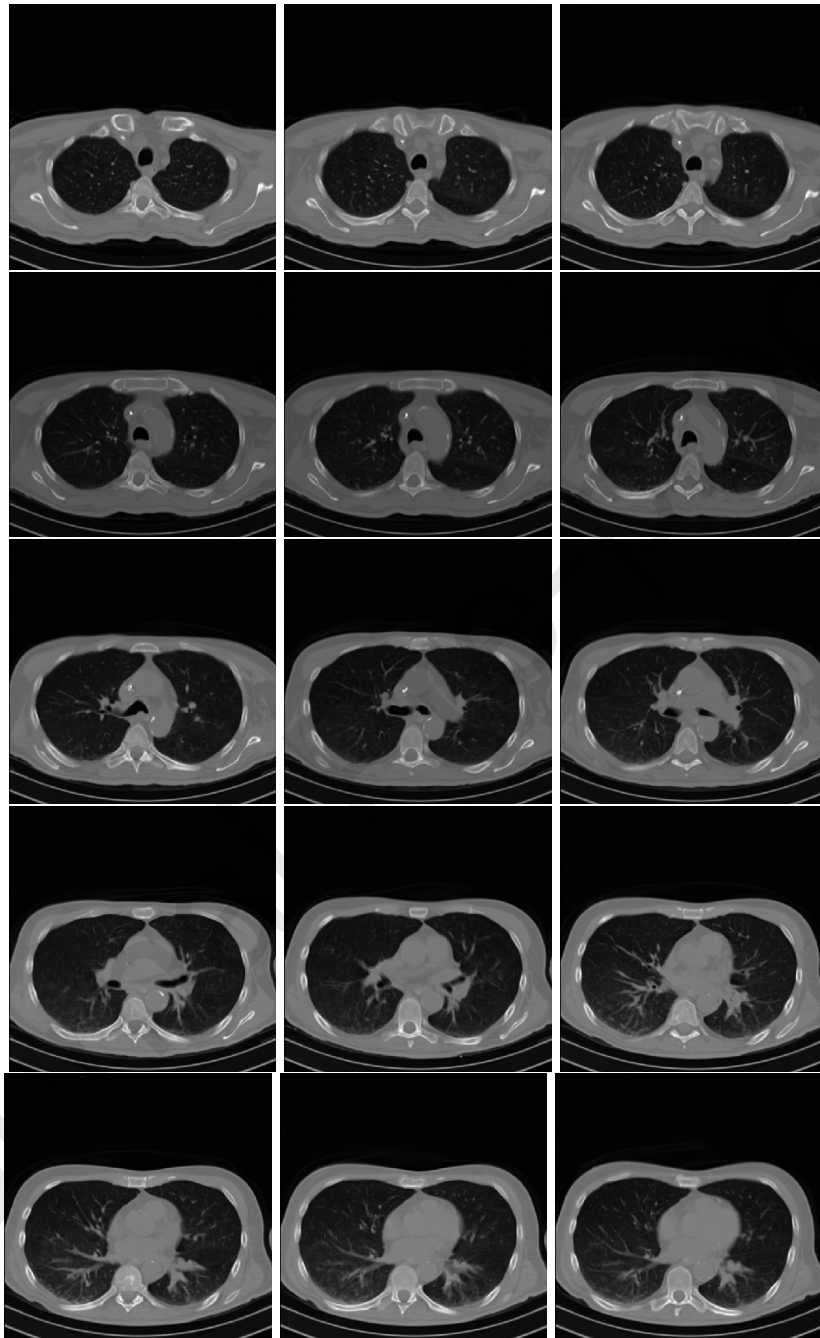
Slices from a non COVID-19 CT scan in COV19-CT-DB
